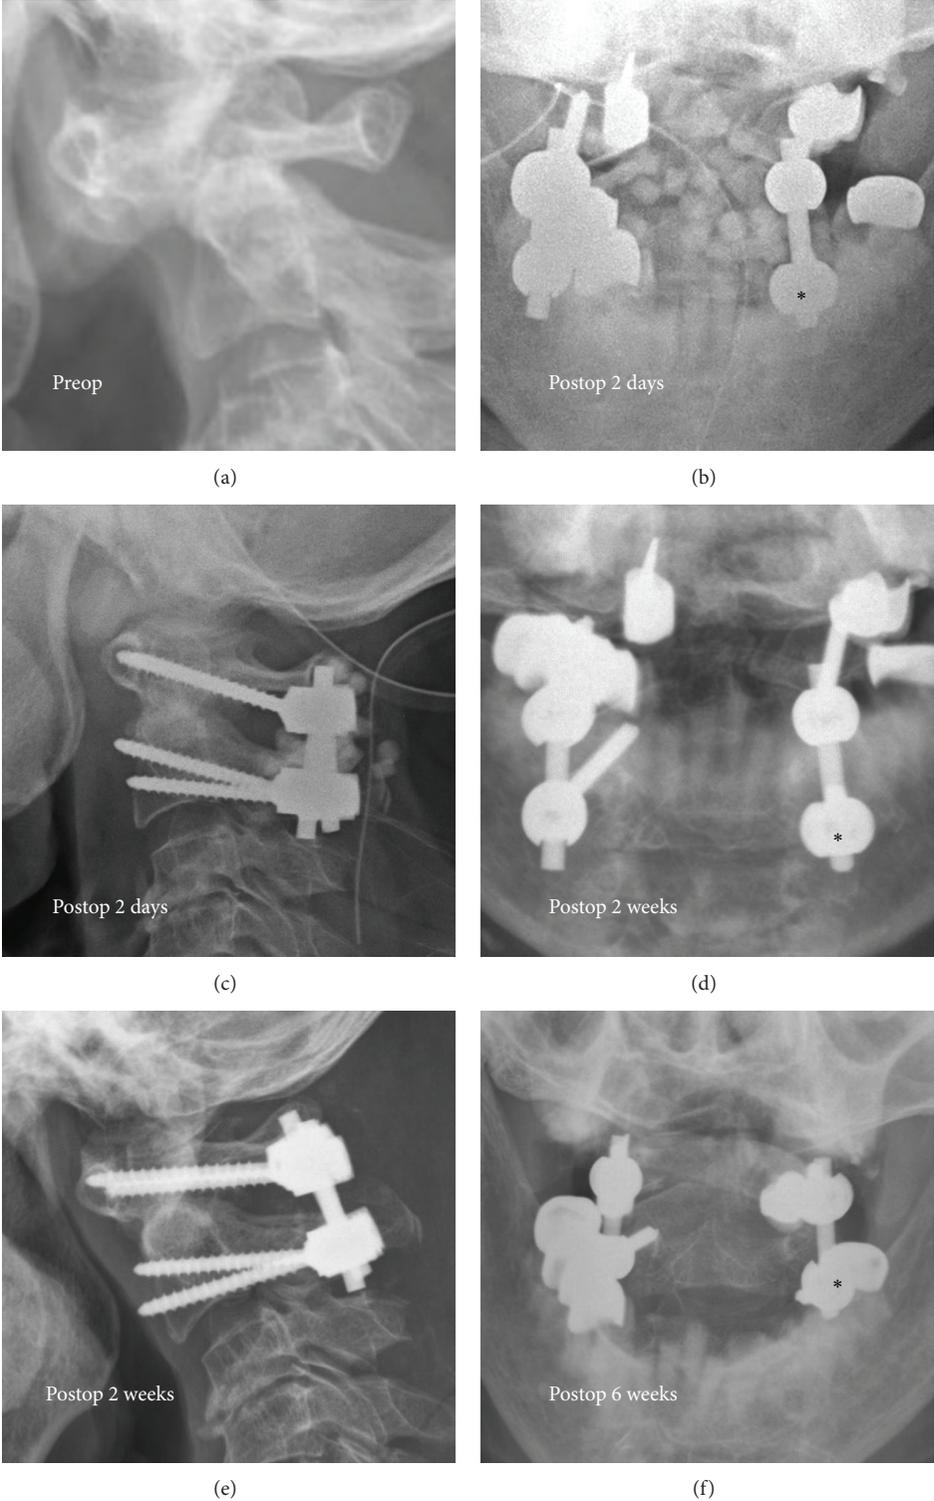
Preop lateral radiograph revealed AAI (a). Second day postop radiographs showed malposition of left C2 screw (*asterisk*) ((b) and (c)). Two weeks postop radiographs for follow-up of the fusion condition ((d) and (e)). Six weeks postop open mouth radiograph revealed loosening of left C2 screw (f).
